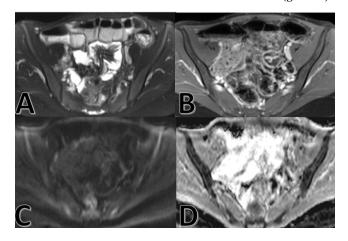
A case of in-active chron's disease. A: axial T2 with fat suppression showed normal mural thickness of the terminal ileum, no edema or ulcers. B: axial post contrast showed no significant enhancement. C & D: axial DWI and ADC showed grade 0 (definitely no lesion)
